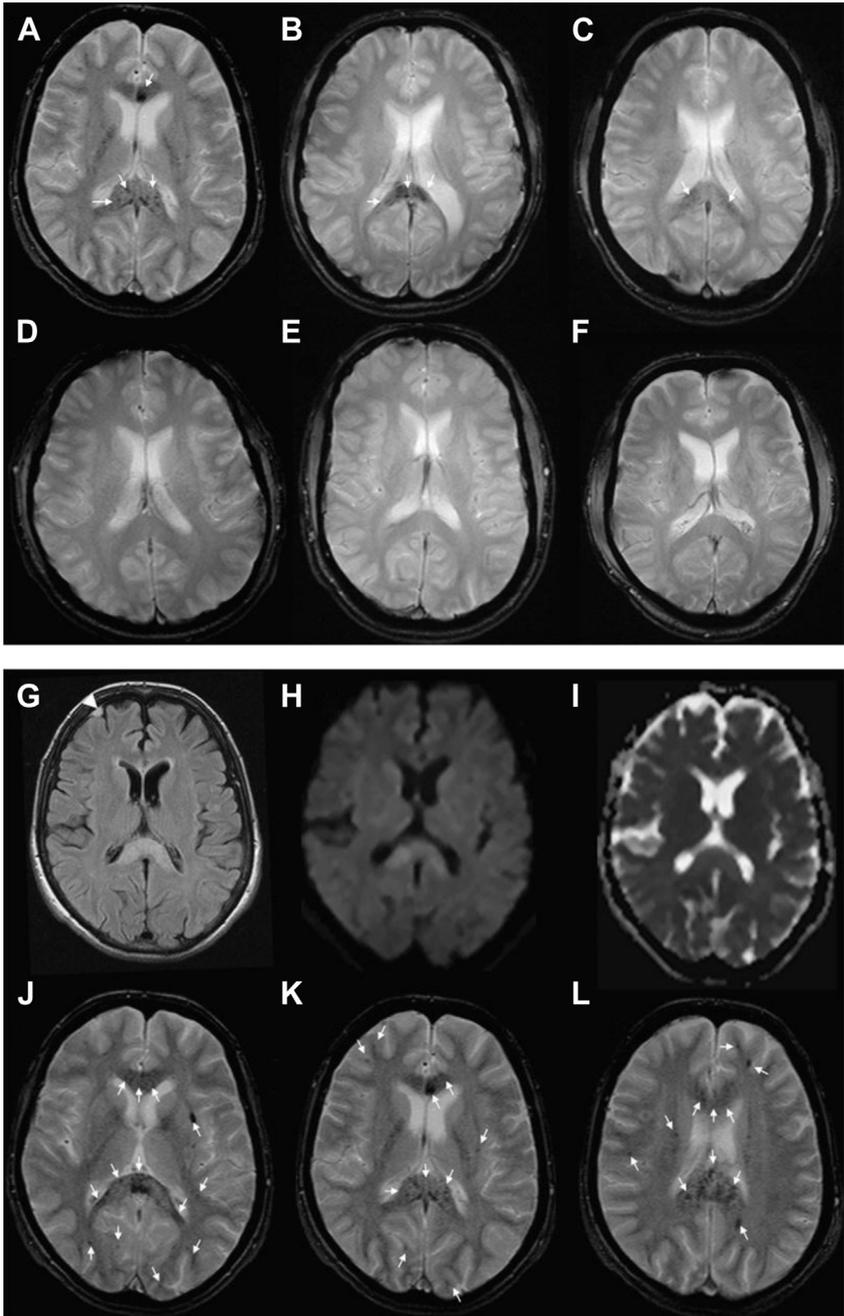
MRI findings representative of HACE. Susceptibility-weighted T2* images show the differences between the normal MRI of acute mountain sickness patients (D–F) and HACE patients (A–C), with multiple lesions representing hemosiderin deposits predominantly located in the splenium of the corpus callosum (arrows). Fluid-attenuated inversion recovery (FLAIR) (G) shows edema in the corpus callosum. The right frontal meningioma (arrowhead) is an incidental finding. Areas of edema are confirmed by diffusion-weighted imaging (H), with increased values in the apparent diffusion coefficient (I), indicating increased water diffusivity compatible with vasogenic edema. Multiple microhemorrhages consistent with hemosiderin deposition (arrows) are displayed on the T2* images (J–L).
